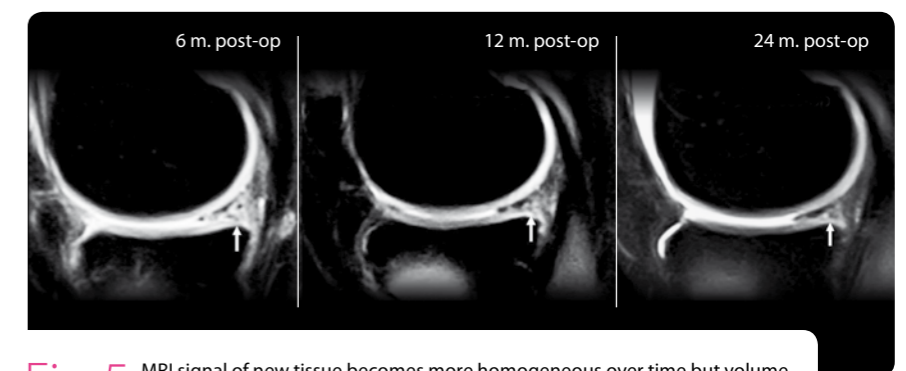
MRI signal of new tissue becomes more homogeneous over time but volume is reduced or compressed. Courtesy of M. Ronga and E. Genovese, Varese (IT)
